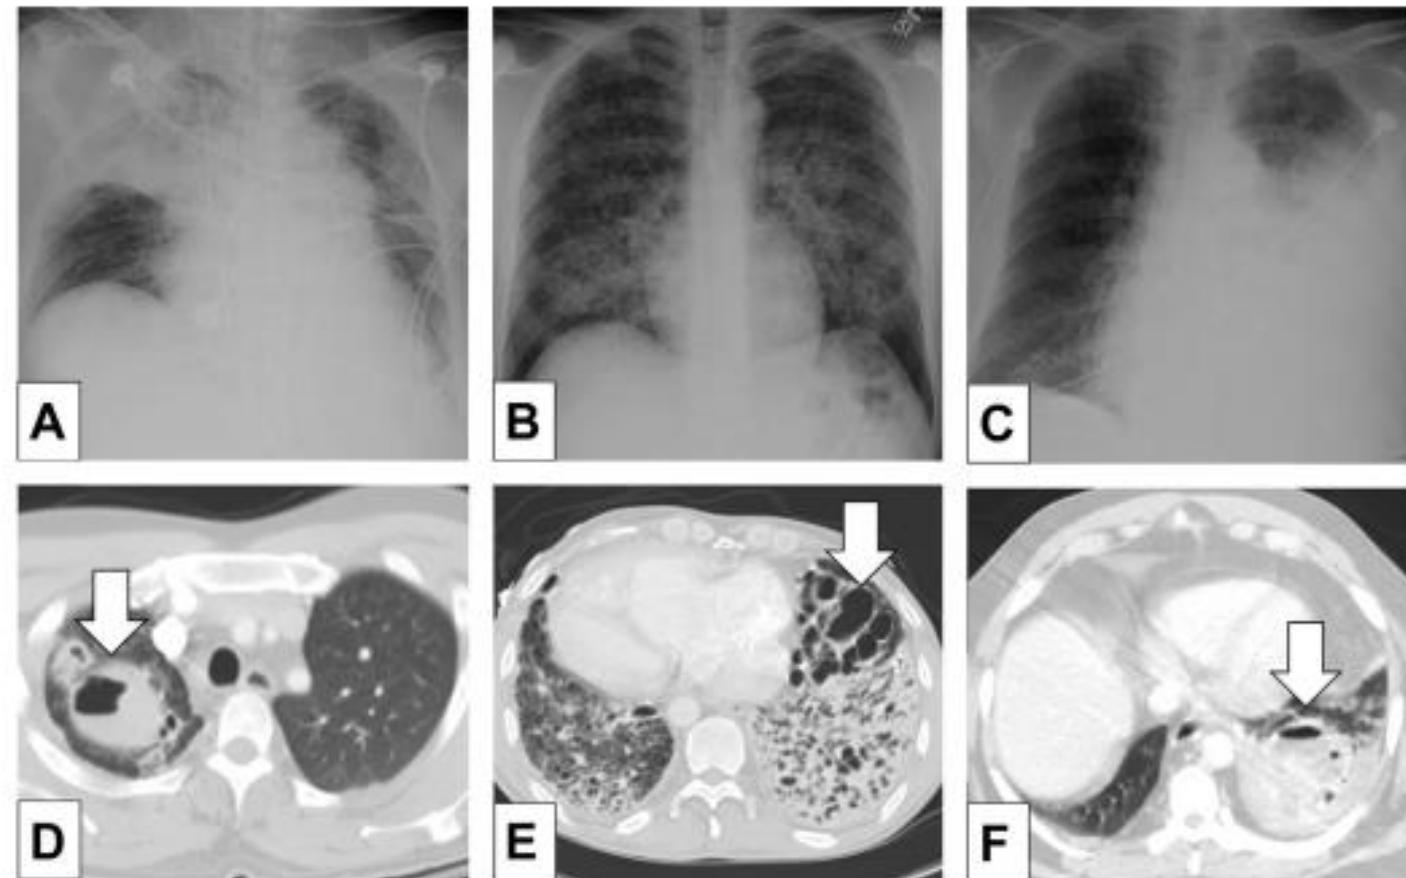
Variations in radiographic appearance of pneumonia. (A) Lobar consolidation of the right upper lobe. (B) Bilateral interstitial infiltrates. (C) Large left parapneumonic pleural effusion. (D) Right upper lobe cavitary lesions (white arrow). (E) Diffuse bronchiectasis involving primarily the anterior left lower lobe (white arrow). (F) Pulmonary abscess with air fluid level in the posterior left lower lobe (white arrow).
